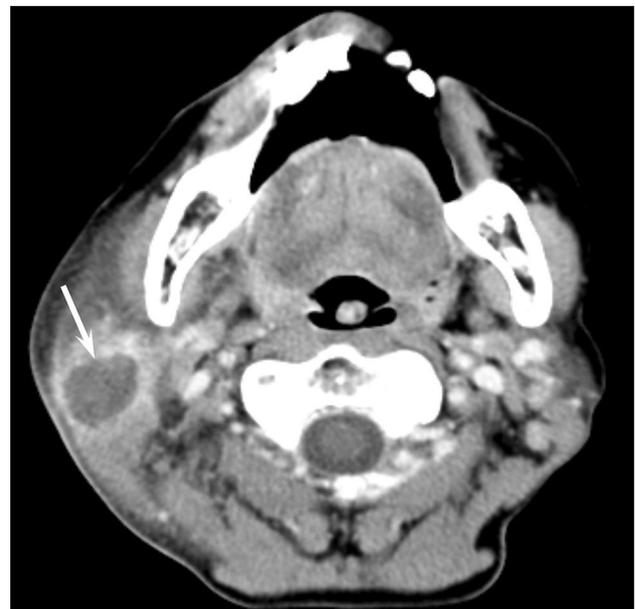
A 64-year-old woman with abscess of the parotid gland. Contrast-enhanced CT image shows a cystic lesion (arrow) with enhancement of surrounding soft tissue in the right parotid gland
